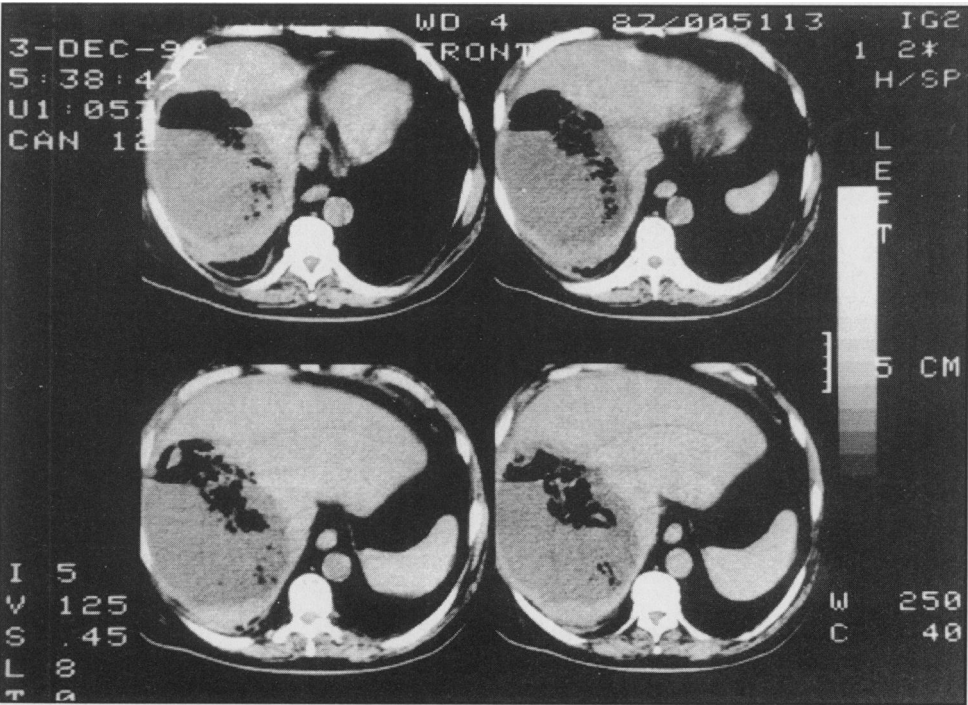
CT scan showing hepatic abscess with gas in liver substance.
